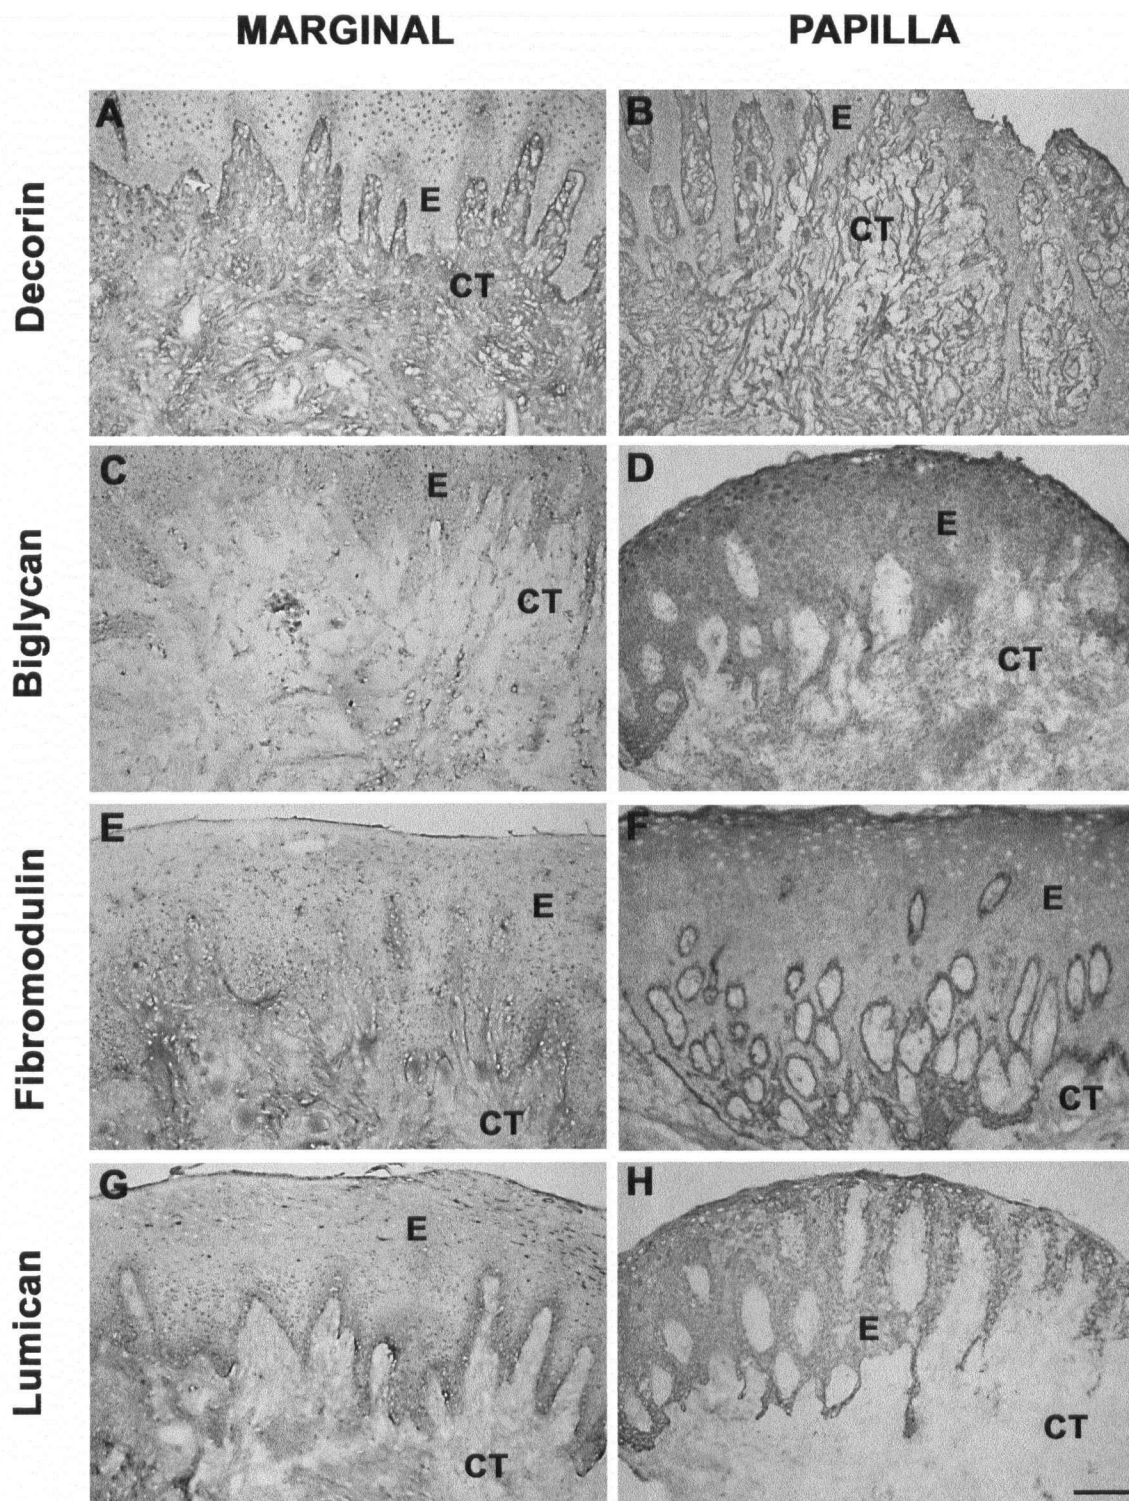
Immunolocalization of decorin (A and B), biglycan (C and D), fibromodulin (E and F) and lumican (G and H) in healthy marginal gingiva (A, C, E and G) and interdental papilla (B, D, F and H). E = epithelium; CT = connective tissue. Bar 100 μ m
